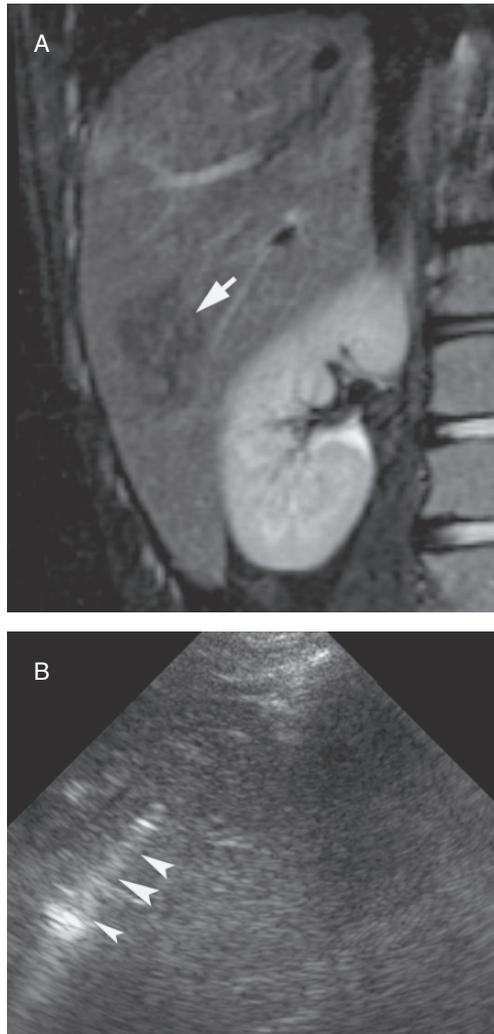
Hepatic adenoma primarily treated with radiofrequency ablation (RFA). (A) Coronal MRI of the right hepatic lobe demonstrate the focal mass, proven to be hepatic adenoma by percutaneous core needle biopsy (arrow). (B) Sonographic image during RFA demonstrates the RF needle probe (arrowheads) in the adenoma at the beginning of the ablation treatment. (C) CT scan 1 year following treatment demonstrates focal scar (arrow) at the site of the RFA with no residual tumor (CT and MRI 2 years later demonstrated further retraction of the hepatic scar and no recurrent tumor).
